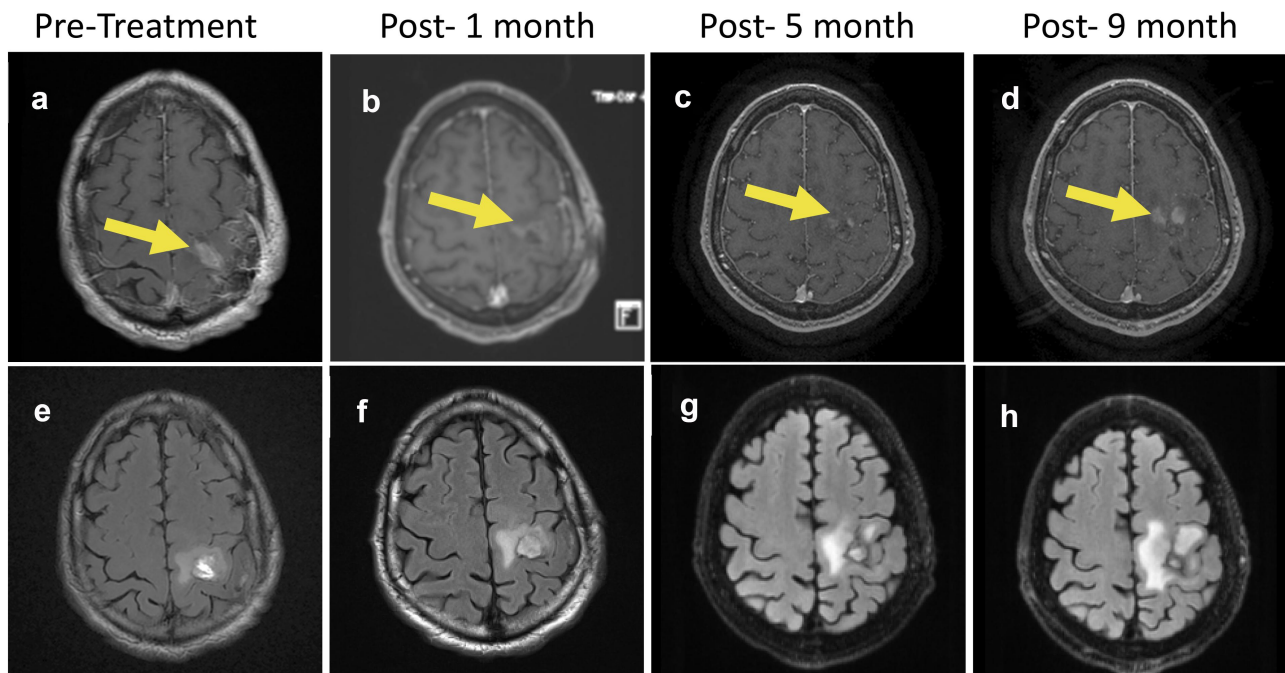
Magnetic resonance imaging of patient 301. Brain MRI shows axial T1 post-gadolinium images (a-d) and corresponding T2-FLAIR images (e-h) of a left frontal residual tumor (arrows) before treatment with nivolumab and ipilimumab (a, e), and 1 month (b, f), 5 months (c, g), and 9 months (d, h) after treatment initiation. The images show improving enhancing disease for over 5 month before progression at 9 months.
